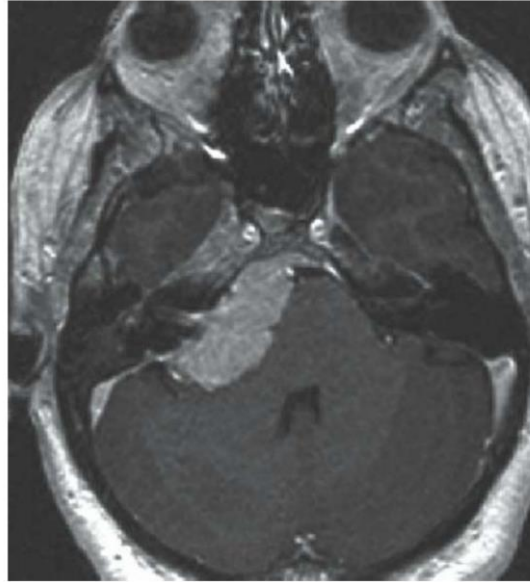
Axial T1-weighted contrast-enhanced MRI image at the level of the IAC demonstrating a right CPA meningioma with broad dural attachment and enhancement.
